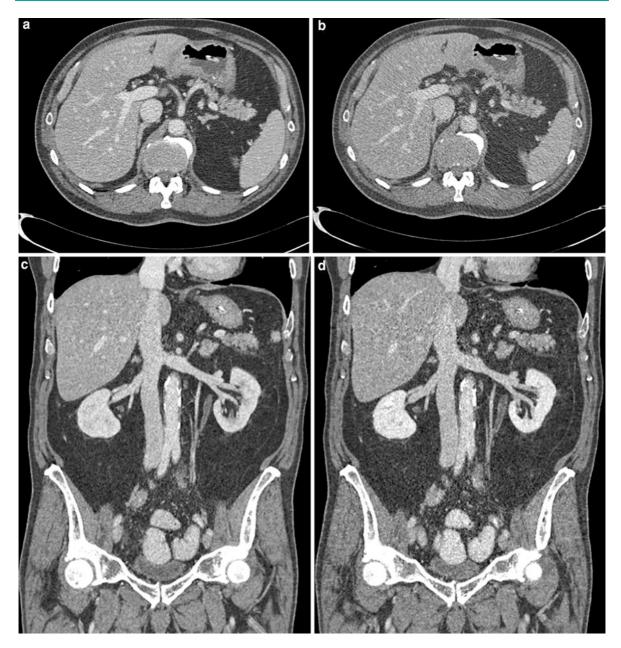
Transverse (a, b) and coronal (c, d) IV enhanced CT images obtained in an 80-year-old-man suspected of small bowel occlusion with a BMI of 26.3 kg/m². A first acquisition (a, c) has been performed at standard-dose CT (120 kVp, 115 effective mAs with AEC; CTDIvol: 8.89 mGy; DLP: 446 mGy cm) directly followed by a low-dose CT (b, d) with reduced tube
